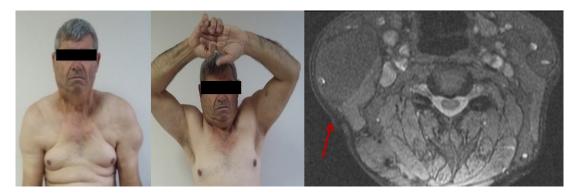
Multiple lipomas on the neck, shoulder girdles, and arms, with limb girdle weakness. Note the lipoma seen in the cervical MRI (red arrow).
